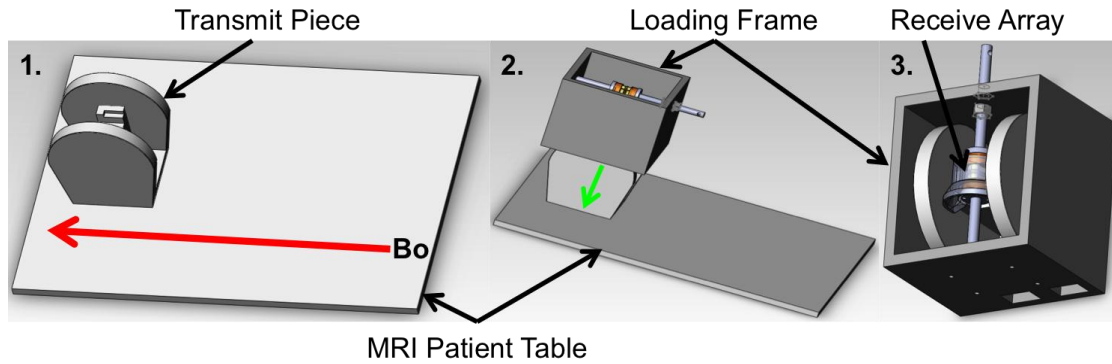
Integration of loading device with MRI and RF coil: (1) Placement of the transmit piece of the coil in the direction of B_0 on the MRI patient table, (2) loading frame slides over the transmit piece, and the (3) receive array slides directly over the disc's location.
